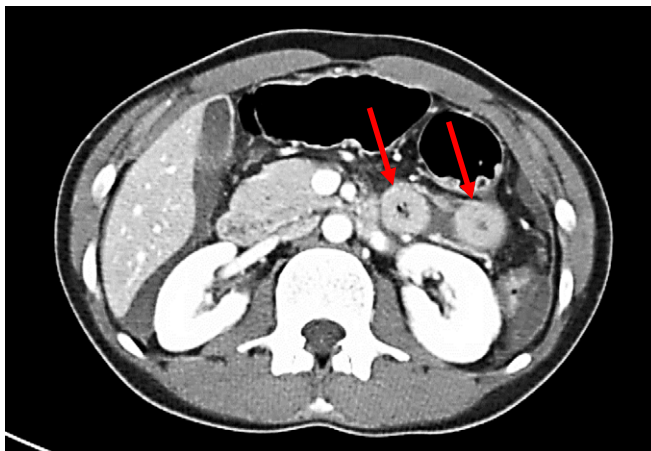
CT of the abdomen (axial view) showing the two ends of the transected jejunum.
